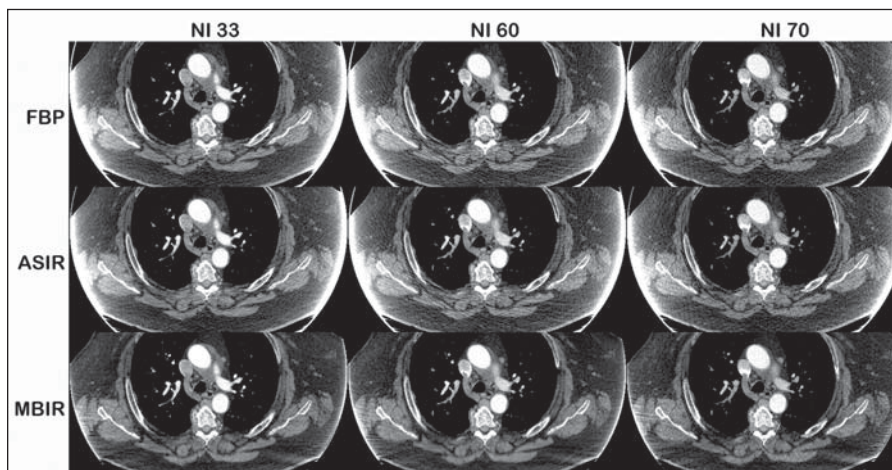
67-year-old woman undergoing CT for follow-up of treated lymphoma. Transverse chest CT images show small volume mediastinal lymphadenopathy reconstructed with different algorithms as shown. Note that edge artifacts related to patient's size are significantly reduced with model-based iterative reconstruction (MBIR). ASIR = adaptive statistical iterative reconstruction, FBP = filtered back projection, NI = noise index.
